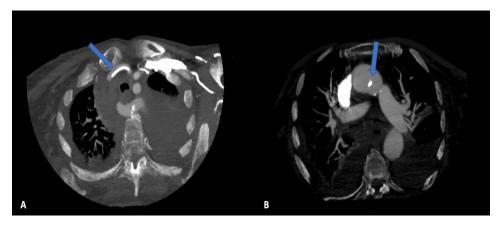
Pre-operative Computed tomography of the chest on axial view showing. (A) the right common carotid artery (CCA) central line coursing through the ascending aorta (arrowhead). (B) Right CCA central line and its incompletely fistulized tip (arrowhead).
